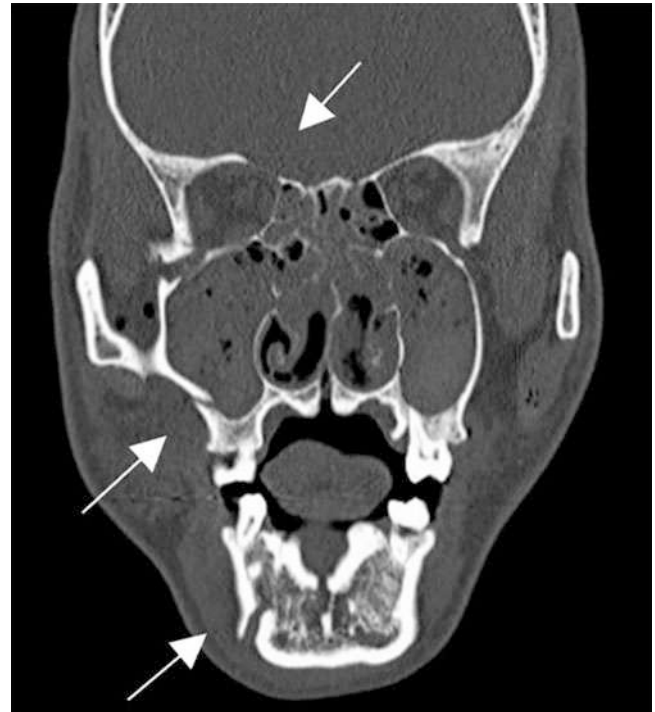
CT scan coronal bone window: Right panfacial fracture with fractures of the upper face (Frontal bone/orbital roof), midface(maxilla), and lower face (mandible)
